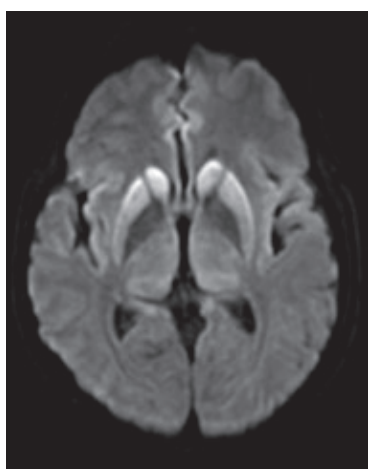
MRI imaging of patient 1 – notable involvement of both caudate nuclei, putamens and thalamic areas
